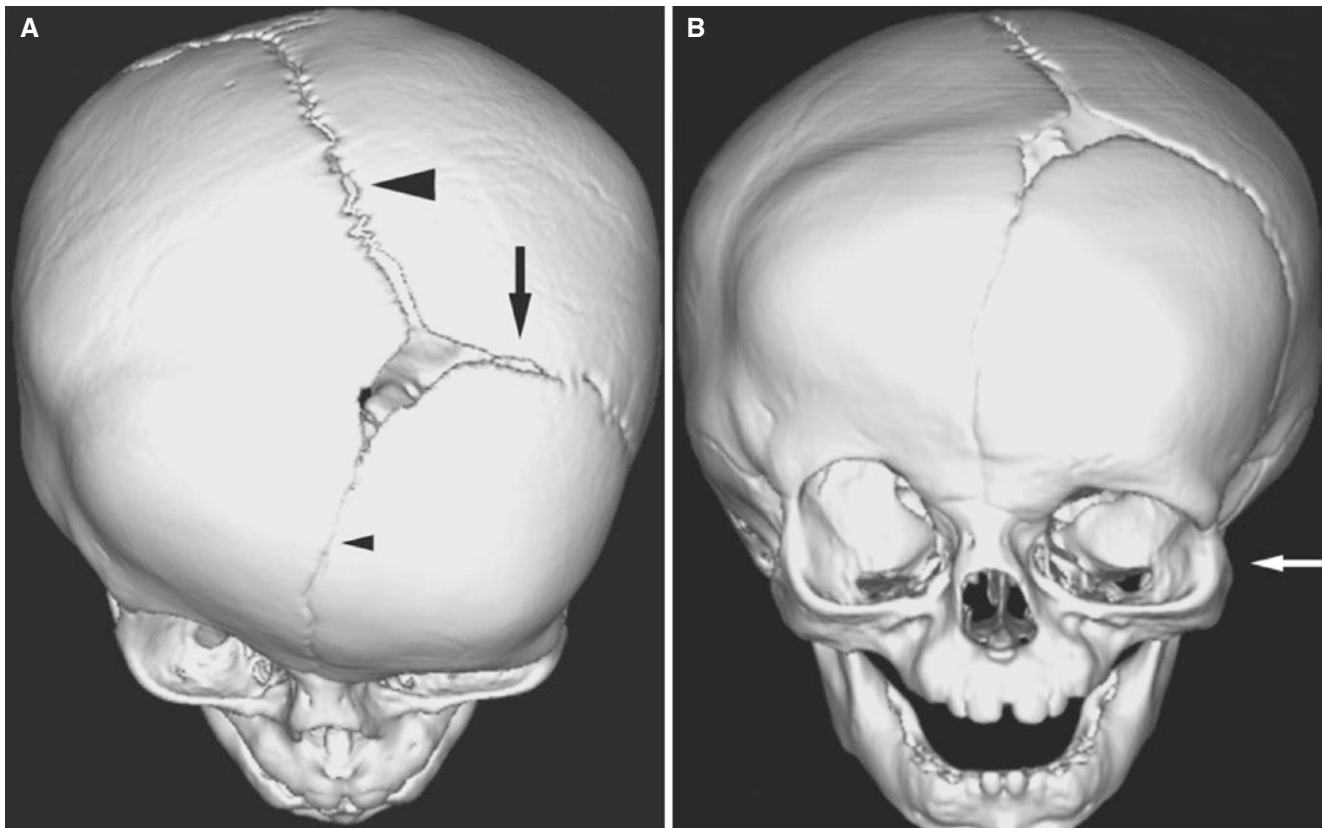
Premature unilateral synostosis, 7-month-old male. (A) 3D CT image shows closure of the right side of the coronal suture but left side open (*arrow*), as is sagittal suture (*large arrowhead*). Anterior fontanelle open and metopic suture closed but can be seen (*small arrow-*
